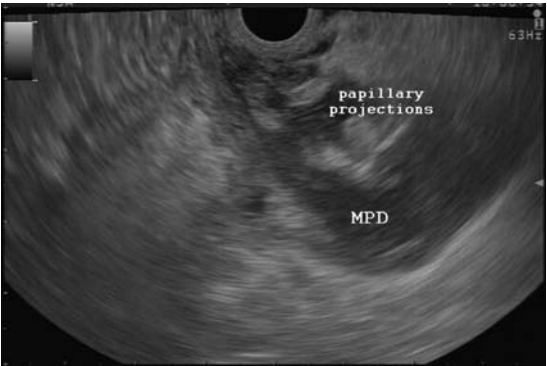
Endoscopic ultrasound.
